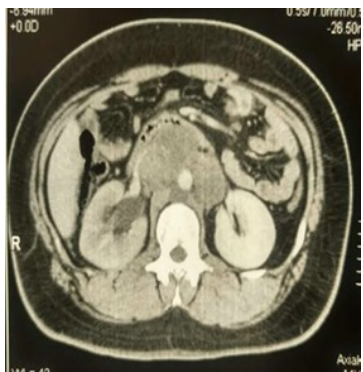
CT SCAN or retroperitoneal mass.
